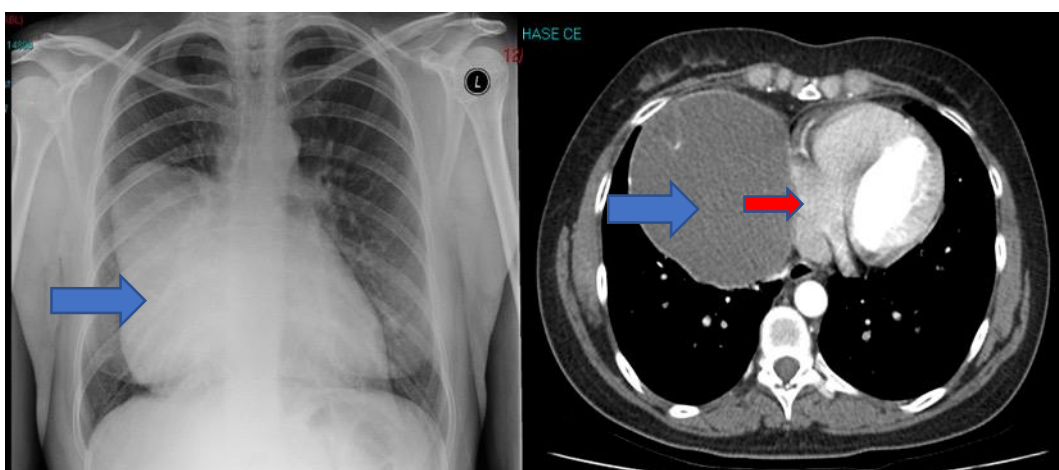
39 year old female presenting with shortness of breath and chest discomfort. Plain radiographs and CT scan showed a thymic cyst (blue arrow) occupying the right hemithorax. The cyst is compressing the right side of the heart (red arrow)
